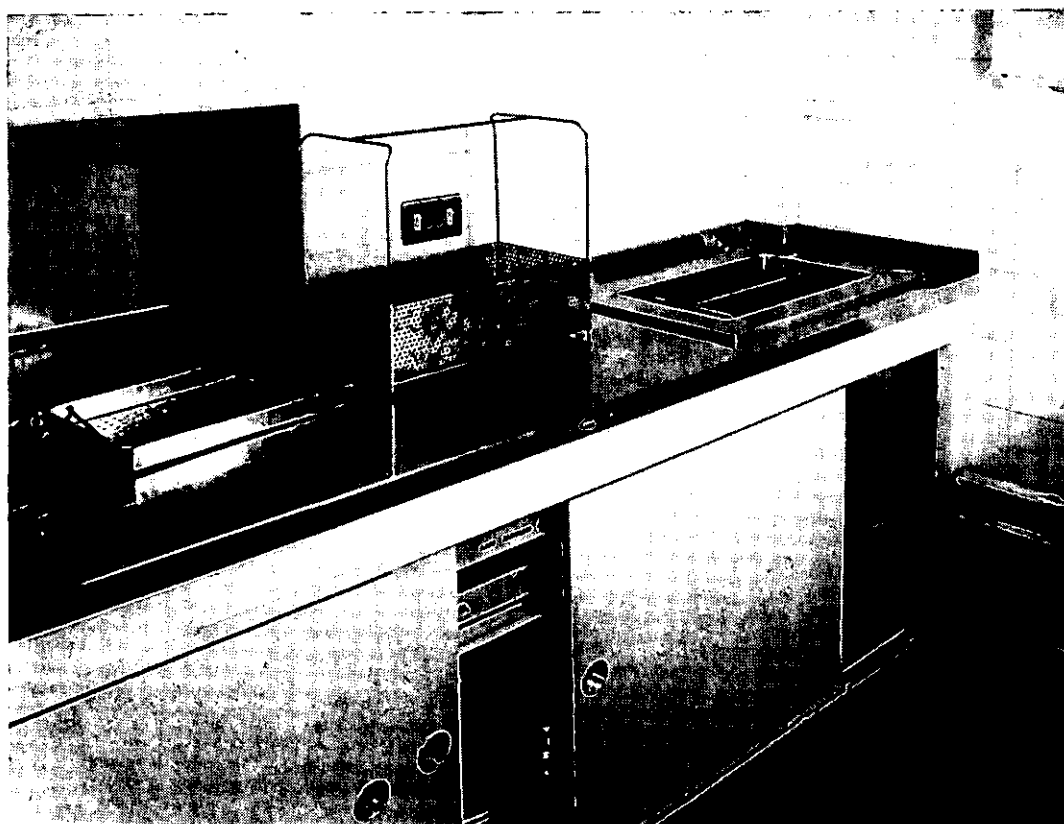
Removing surgical instruments from the ultrasonic tank
